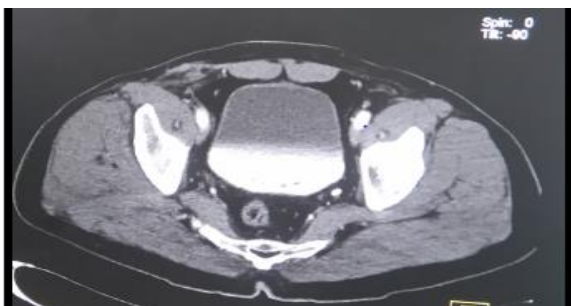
Axial post-contrast CT delayed image showing partial filling of the bladder with contrast.
